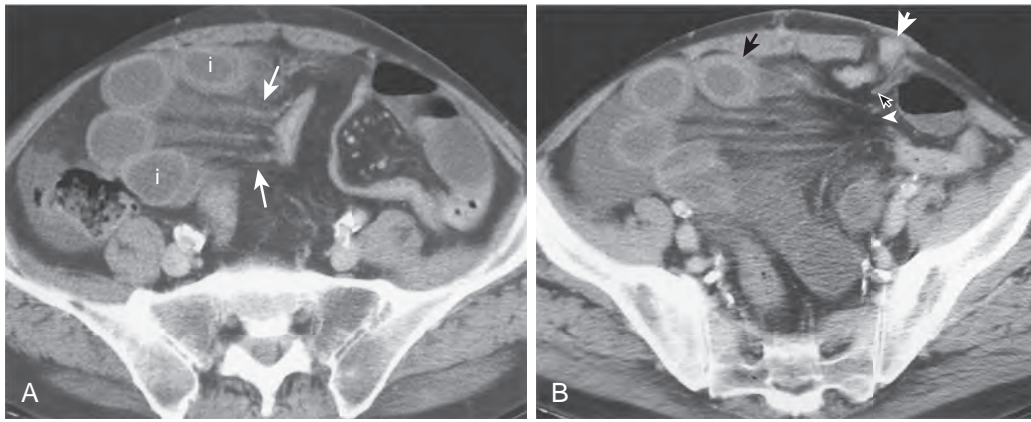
CT scan demonstrating Spigelian hernia resulting in closed loop obstruction with strangulation. A. Axial image through pelvis demonstrates four loops of intestine (between the *i*), with their mesentery (arrows) radiating toward the midline. Haziness of the small bowel mesentery results from vascular engorgement. B. Axial image just caudal to A demonstrates the mesentery radiating toward the left anterior abdominal wall (arrowhead). The radially arranged bowel has a thick wall with a mural stratification pattern (black arrow), indicative of minimum submucosal edema caused by ischemia. A loop of intestine is trapped in a Spigelian hernia (large white arrow). The loop exiting the hernia is abruptly angulated (open arrow). The site of volvulus is indicated by the open arrow and arrowhead. At surgery, a twist at the loop exiting the Spigelian hernia resulted in irreversible small bowel ischemia.
